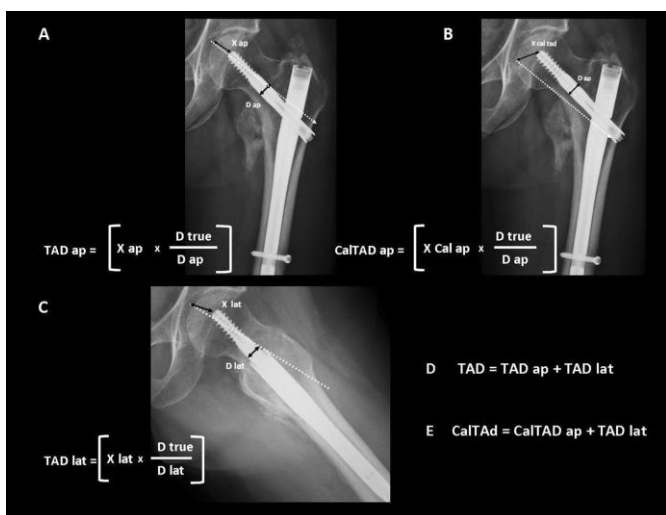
Measurement of TAD at 6 weeks on digital X-rays using the reference method described by Johnson *et al.*
